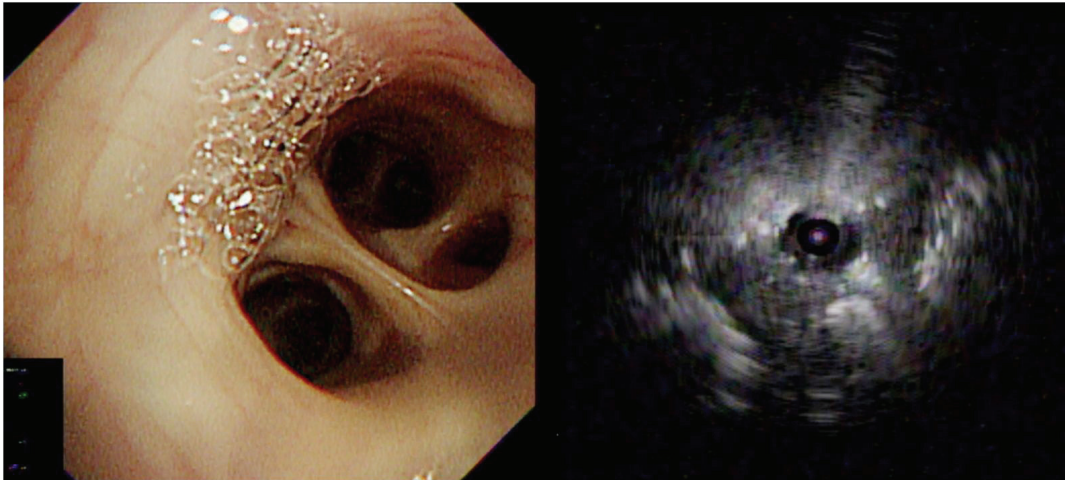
Bronchoscopy showed no endobronchial lesion, lumen stenosis or mucosal change within visible range (a), but endobronchial ultrasonography revealed an atypical bronchus sign with partial consolidation at a 3 cm depth from the orifice of LB10a (b).
